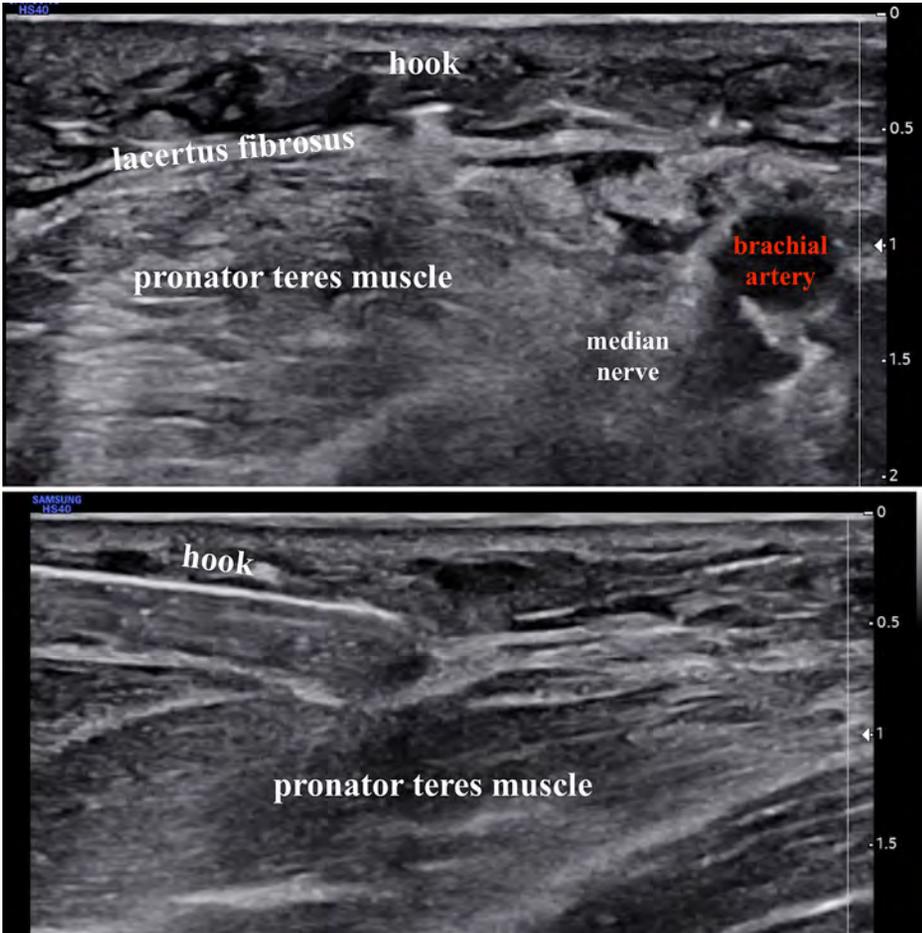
Antegrade technique with a hook for percutaneous ultrasound guided lacertus release at the office under walant.
